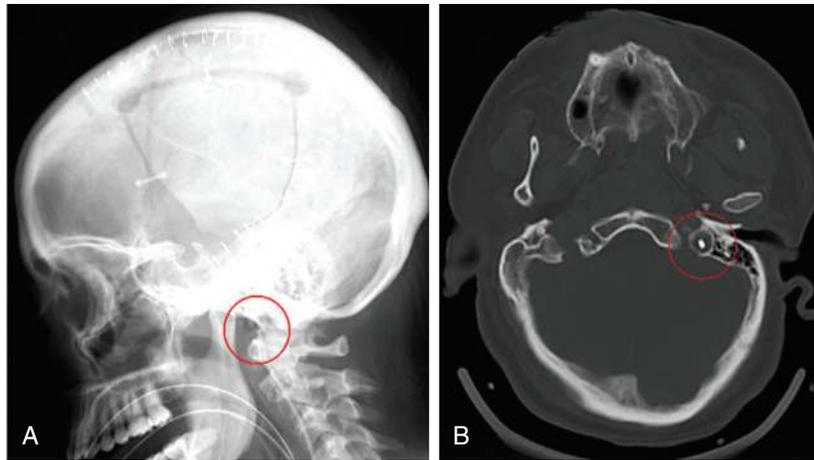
A, Lateral skull x-ray confirming adequate $SjvO_2$ catheter placement at the C1–C2 level. B, Head computed tomography scan showing the catheter tip correctly placed at the jugular venous bulb level.
